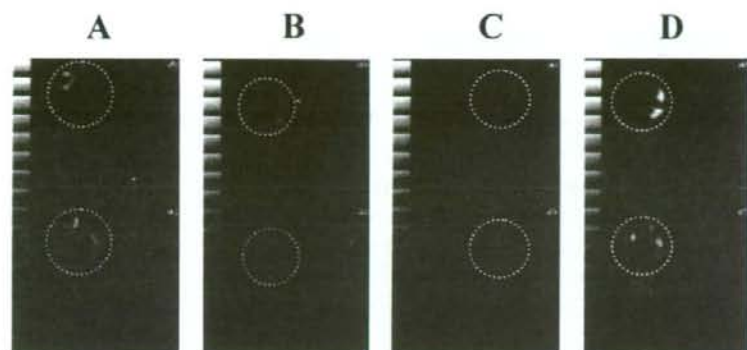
Examples of dual-isotope SPECT imaging after acute MI. Four examples of transverse dual-isotope SPECT images after acute MI (A-D). Upper panels show head side and lower ones show tail side. Red color indicates the uptake of ¹¹¹In-anti-TNC-Fab and green color, the uptake of ^{99m}Tc-MIBI. Myocardium is encircled by yellow broken lines.
